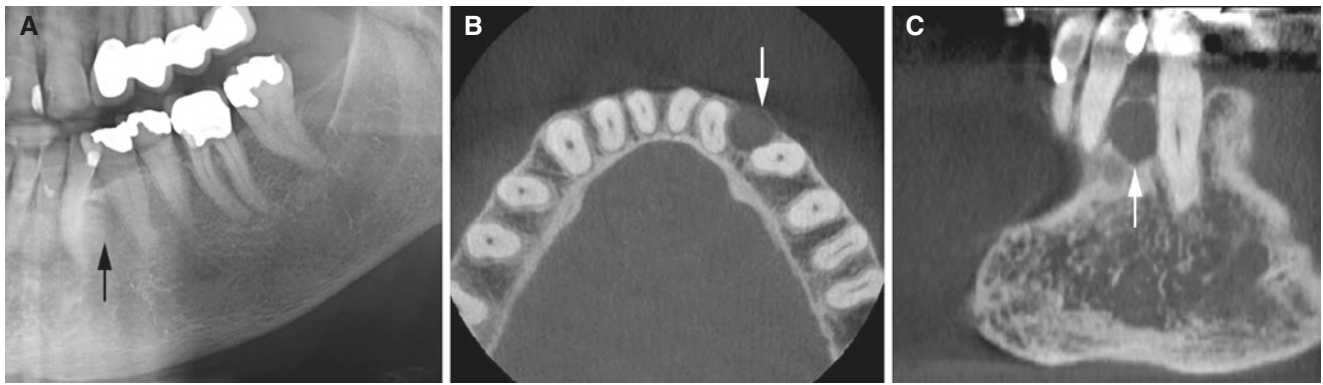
Lateral periodontal cyst, mandible; 70-year-old female with small painless swelling in the anterior part of the left mandible. Vital teeth. (A) Panoramic view shows no evident pathology in area (*arrow*). (B) Axial and (C) Oblique coronal CBCT images show small round
